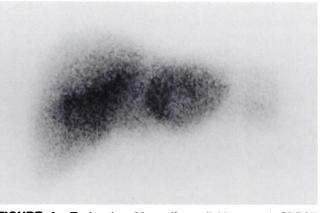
Technetium-99m-sulfur colloid coronal SPECT scan shows a focal area of increased activity in the anterior aspect of the lateral segment of the left lobe of the liver.
